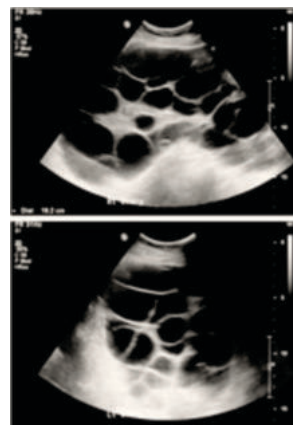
Ultrasound of ovaries in ohss
